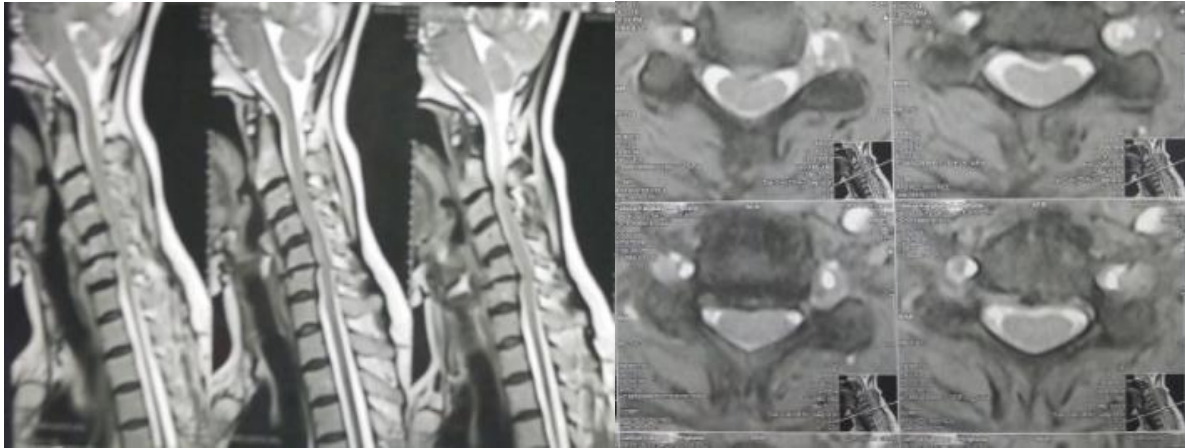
Preoperative MRI sagittal and axial section with cord myelopathy.
